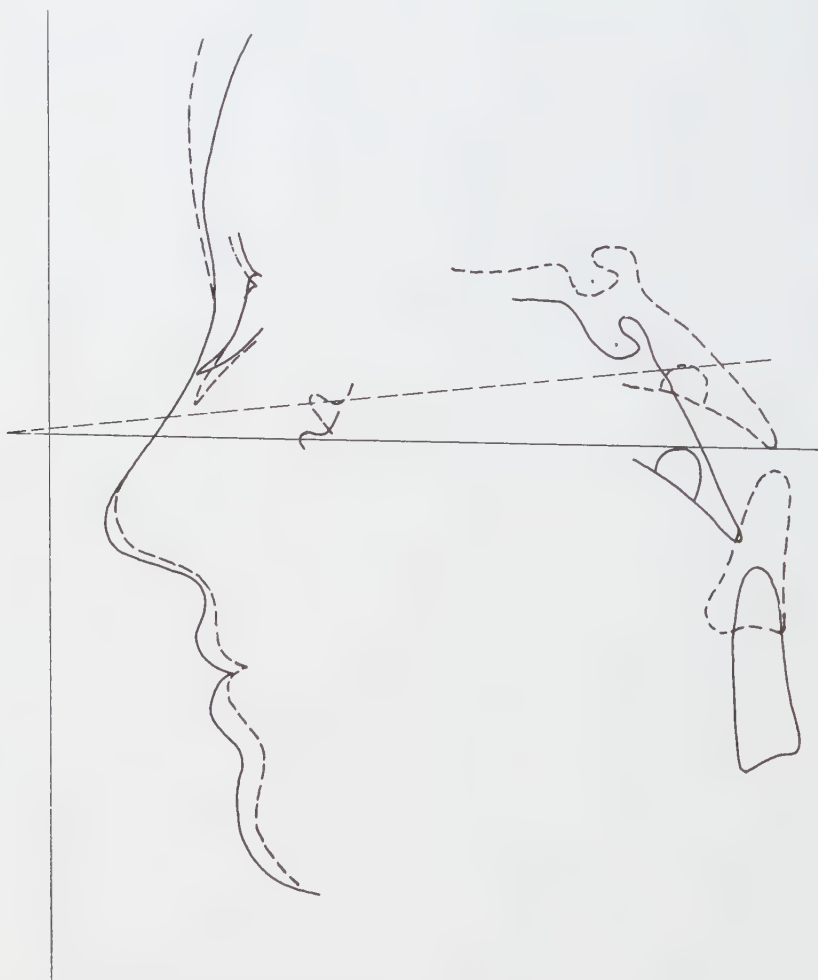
Marked differences in the inclination of the cranial base and Frankfort Horizontal in two females with close similarity in facial profile. The cephalometric radiographs were taken with the head in natural position. The vertical is shown for reference purposes.
